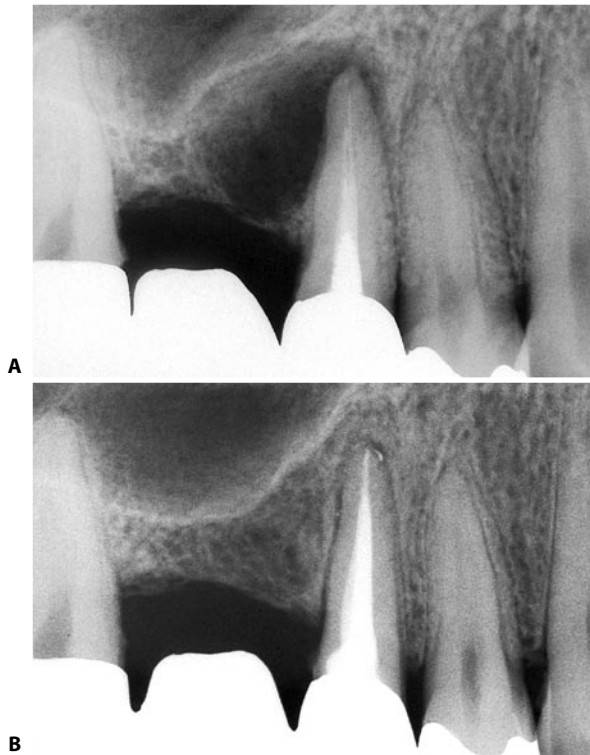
A. Preoperative radiograph of the upper right second premolar. Note that the lesion is particularly pronounced distally. B. Two years following nonsurgical retreatment. The lesion was sustained by a very thin lateral canal which is barely visible radiographically.
